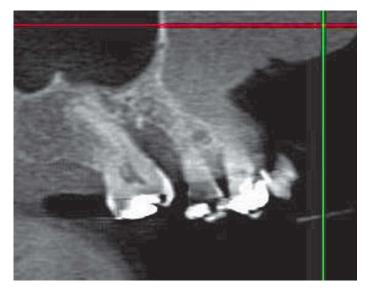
Computed tomography multiplanar reconstructions evincing pulp stone in tooth #27. Sagittal view.
